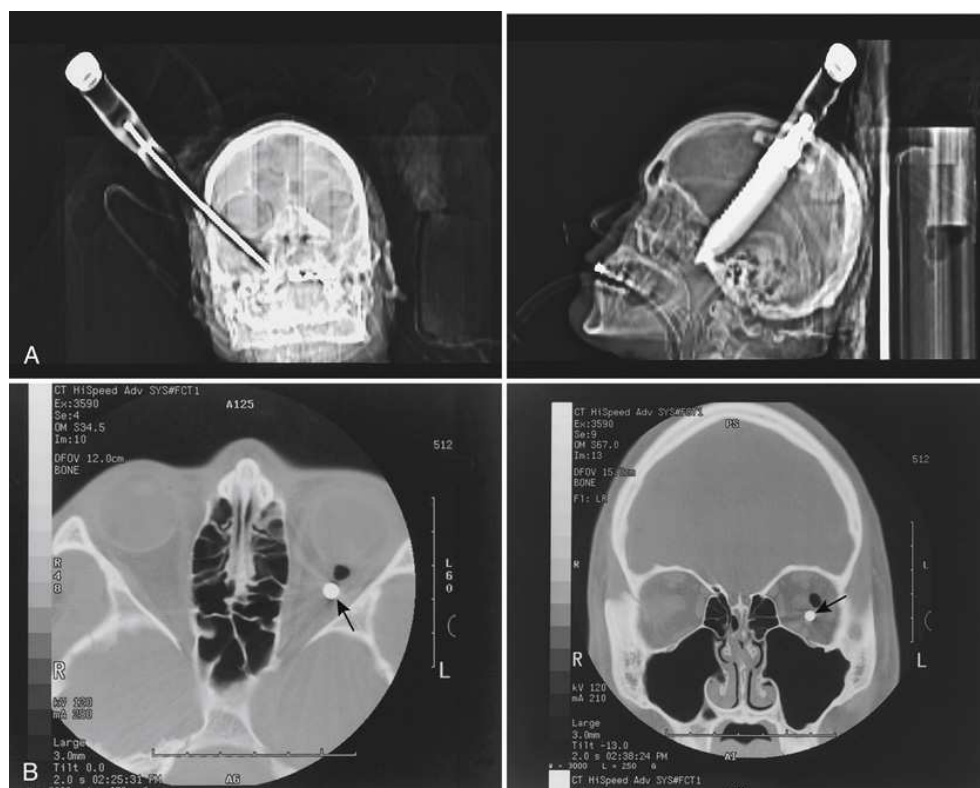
(A) AP and lateral computer tomography (CT) scout images of cranium. Note knife placement in cranium. Conventional cranium radiographs were not obtained on this trauma patient. The patient was sent directly to CT scanner for these images and sectional images before going to surgery. The patient recovered and returned home. (B) Axial and coronal CT sectional images of cranium at level of the eye. The patient was shot in the left eye with a BB gun. Note BB (*arrow*). Adjacent black area is air. The patient now has monocular vision. A, Courtesy Tony Hofmann, RT[R][CT], Shands Hospital School of Radiologic Technology, Jacksonville, FL; B, courtesy Mark H. Layne, RT[R].
